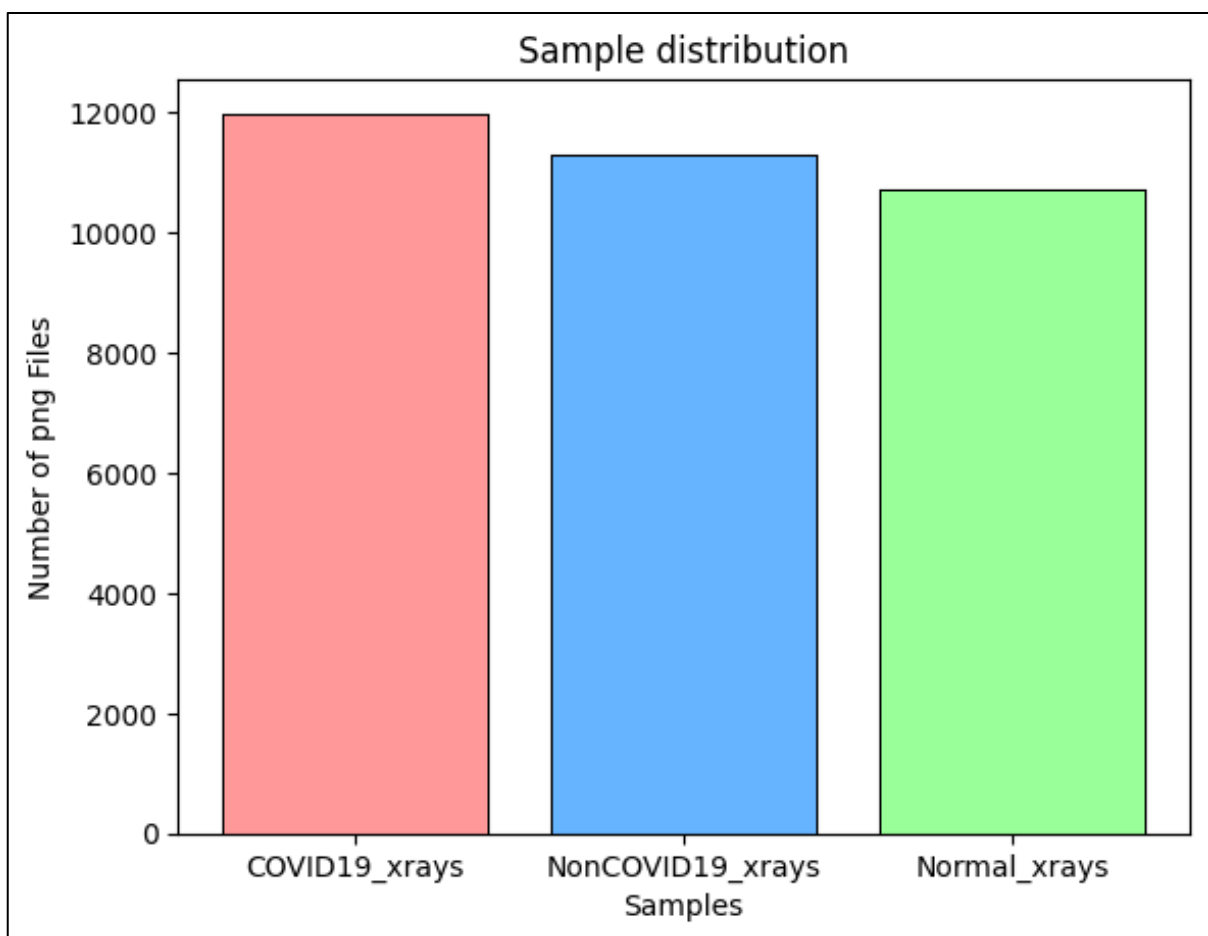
Distribution of X-ray Samples:
